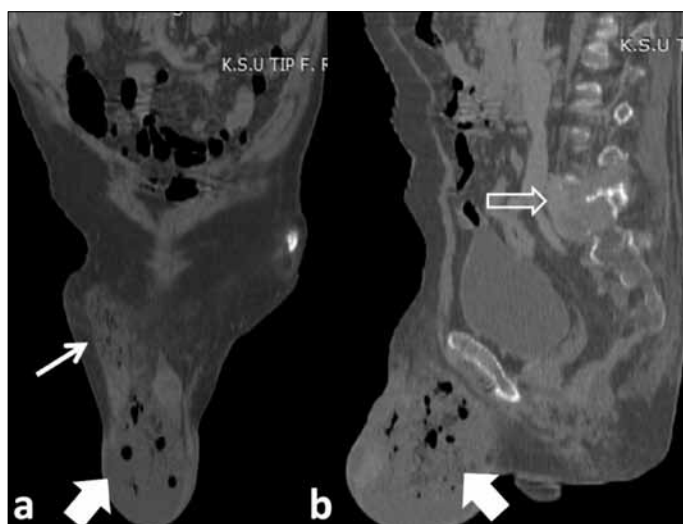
Figure. Coronal (a) Reformatted CT Image Shows a Complex Fluid and Gas Collection Extending From the Scrotum (Thick arrow) Into the Inguinal Canal (Thin Arrow). Sagittal Plane View (b) Shows an Expansile Lytic Lesion at the L5 Vertebral Body, with Associated Plasmacytoma (Open Arrow) and Scrotal Abscess (Solid Arrow)
